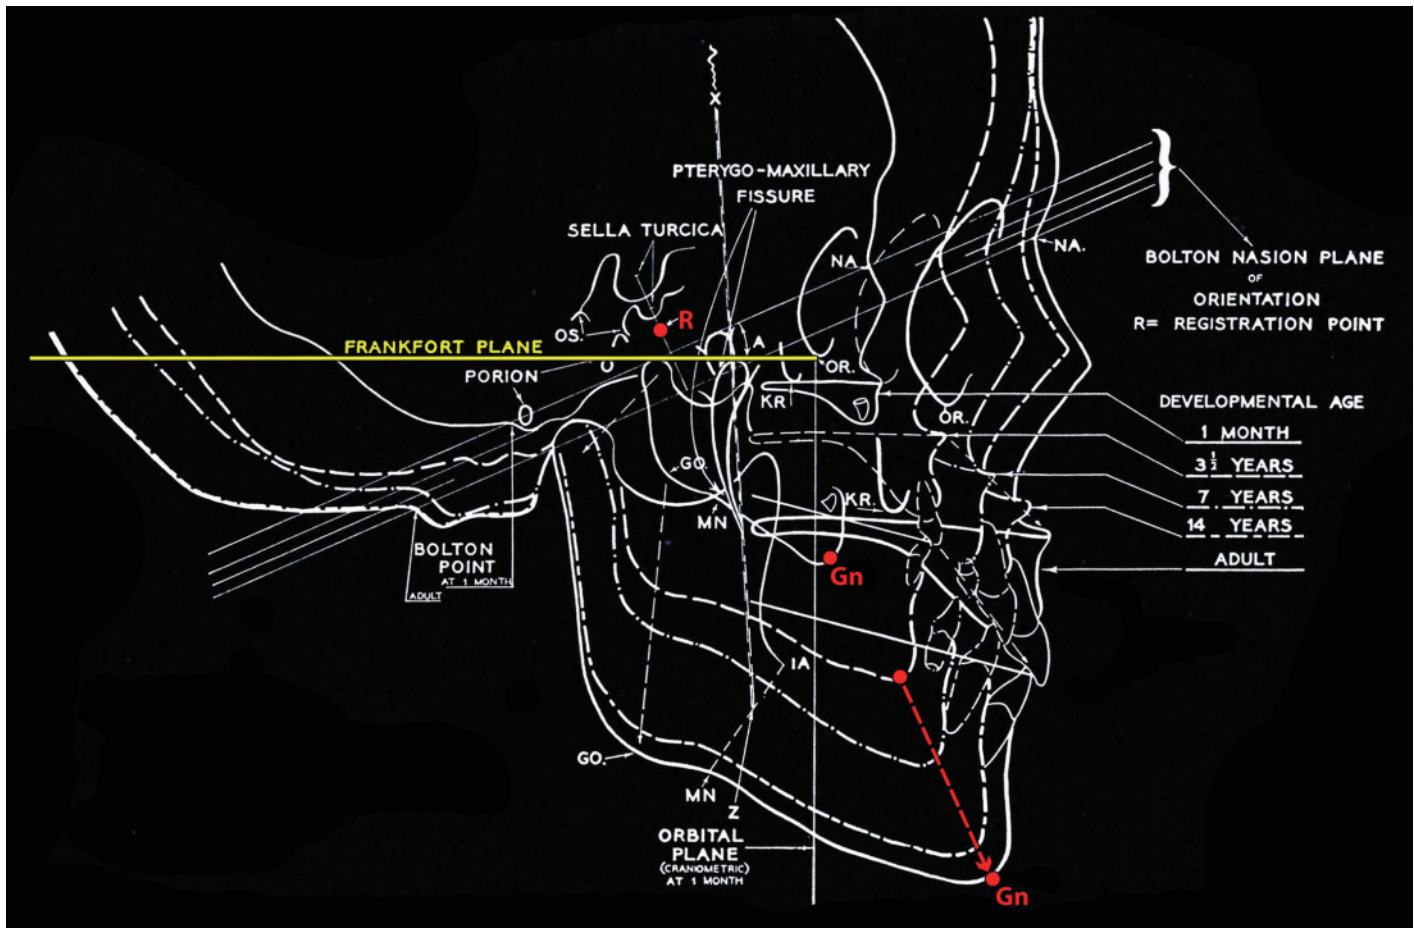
'Normal' or average growth of the face from Broadbent's serial growth study, superimposing serial lateral cephalometric radiographs from the Bolton study records. Broadbent superimposed the radiographs on what he termed R-point (registration point) such that the Bolton planes were parallel. The forward and downward growth of the jaws is evident. (Modified with permission from Broadbent,¹⁴ © The EH Angle Education and Research Foundation.)
